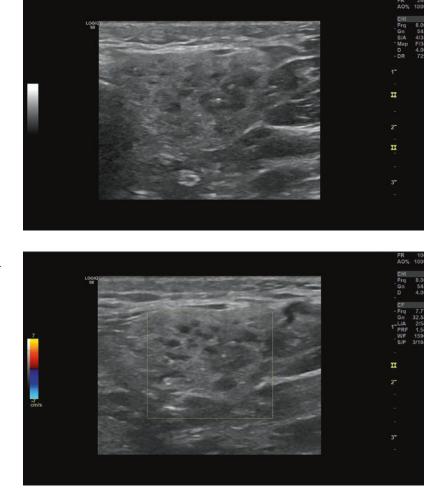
The same lesion with the pattern of spot-like appearance of areas within the glandular parenchyma characteristic of inflammation but with the use of color Doppler. It is readily visible that there is no alterations on the vascularity of the lesion. An intraglandular lymph node is also present
